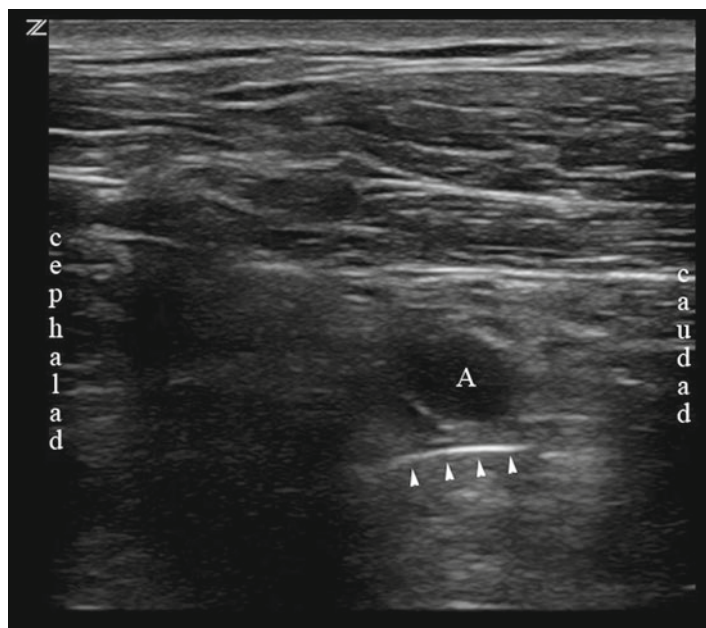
Ultrasonographic appearance of a continuous infraclavicular catheter inserted with ultrasonography (A axillary artery, *arrows* indicate catheter)
